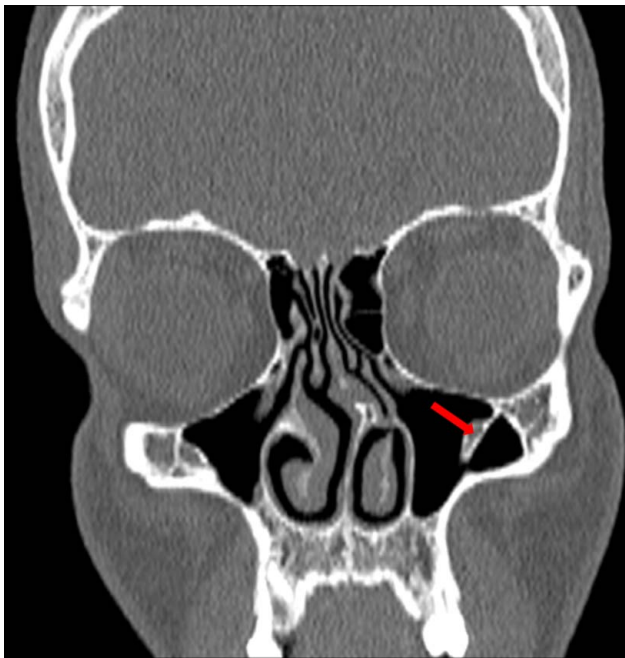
Coronal section CT image showing the IOC within the sinus maxillaries. CT indicates computed tomography; IOC, infraorbital canal.
